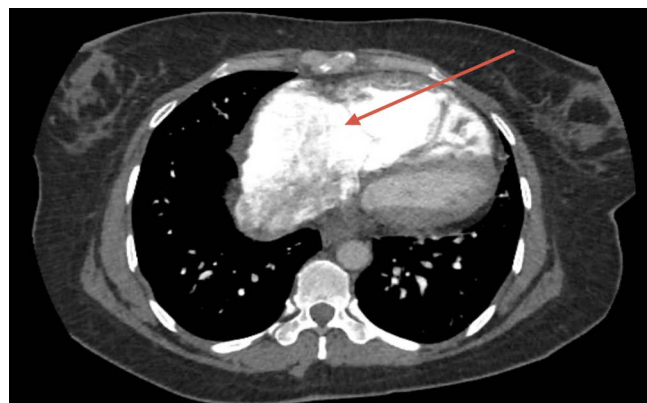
CT Chest Axial view, mediastinal window demonstrating dilated right ventricle (red arrow) suggestive of pulmonary hypertension
